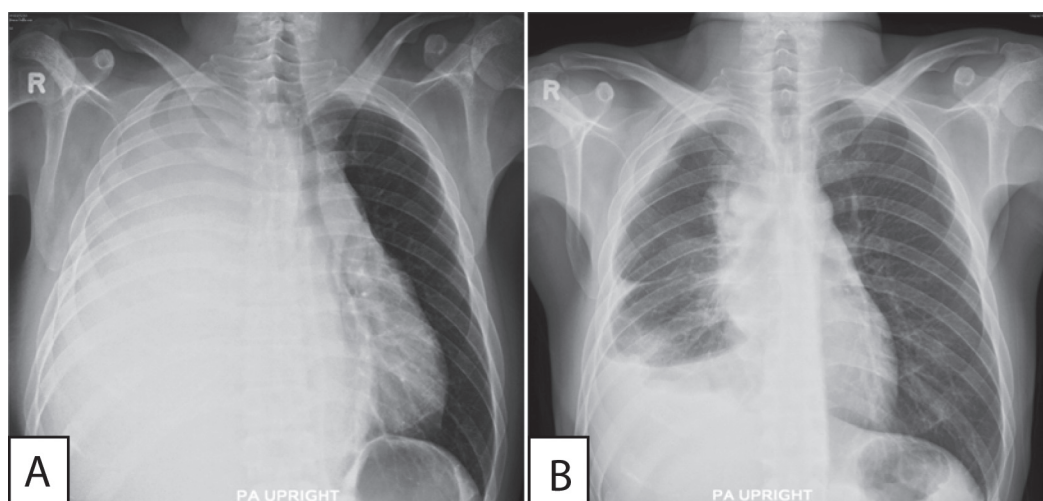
A) Chest X-ray at initial presentation B) Chest X-ray after 2 cycles of chemotherapy
